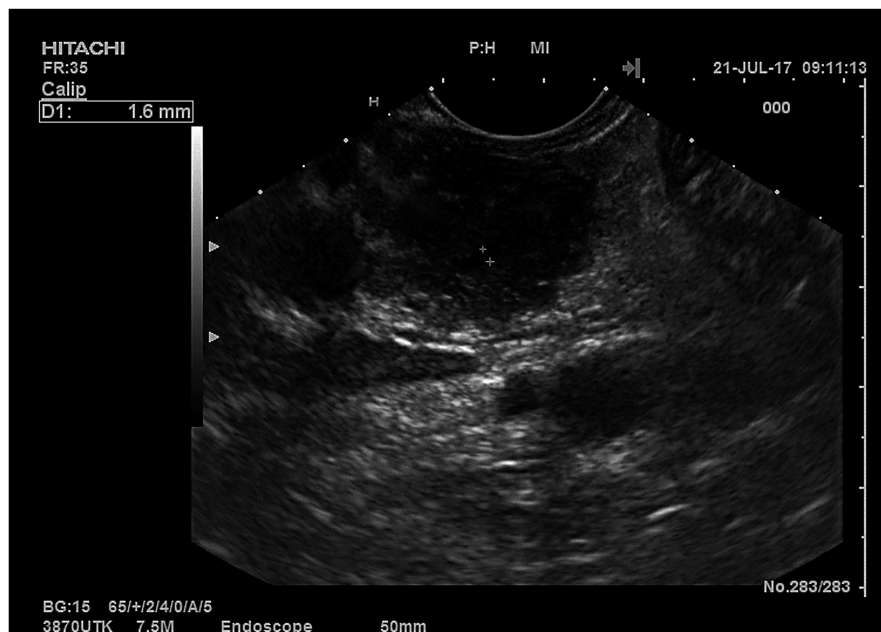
Endoscopic ultrasound appearance of autoimmune pancreatitis (AIP). The image shows the head of the pancreas examined from the duodenum with a diffuse coarse and hypoechoic appearance (sausage-shaped) in a patient with type 2 AIP. The main pancreatic duct was normal (calliper 1.6 mm)
